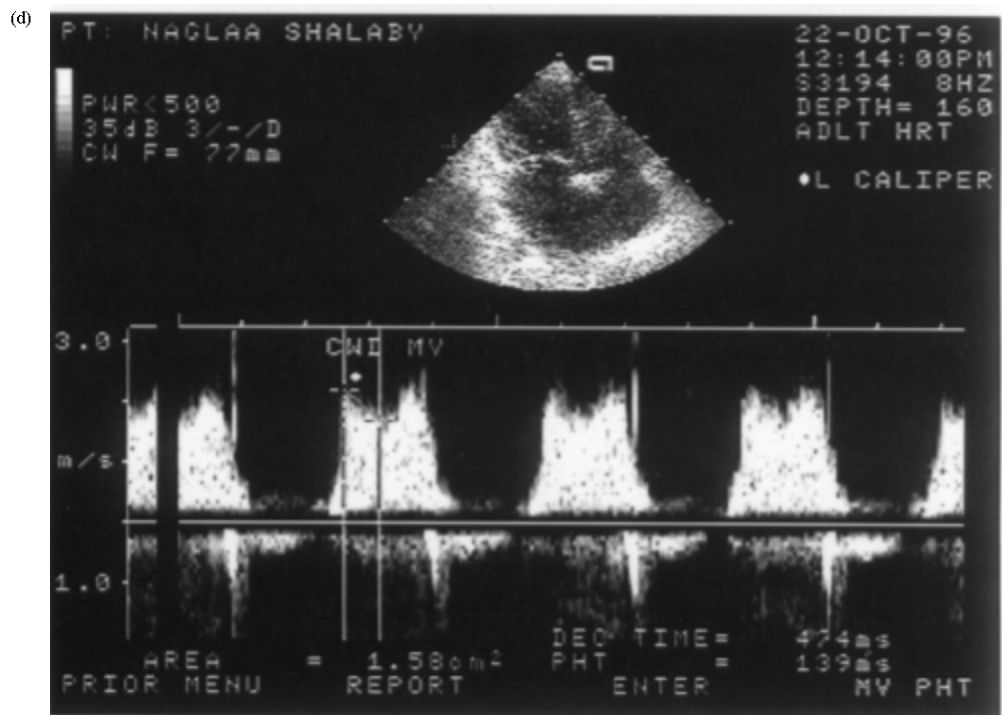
Measurement of MTS and MVA of a patient with mitral stenosis: (a) Long Axis view, (b) Apical 4-chamber view, (c) short axis-MV level and (d) mitral valve CW Doppler
